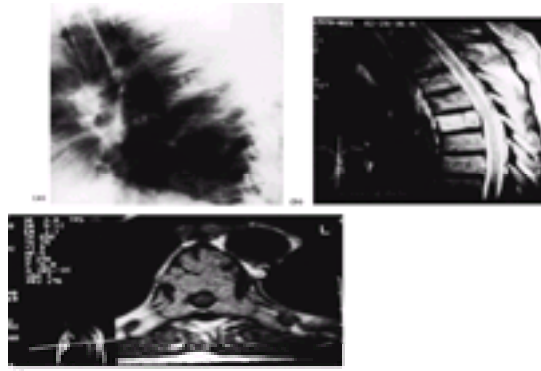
Myeloma. (a) The spine is osteopenic and there is a subtle compression fracture of two vertebral bodies; the patient complained of back pain. (b) On MRI the signal from a single vertebral body suggests an infiltrative process. (c) On axial MRI extensive replacement of the bone marrow is seen; the canal is compromised. A biopsy was positive for malignant plasma cells.
